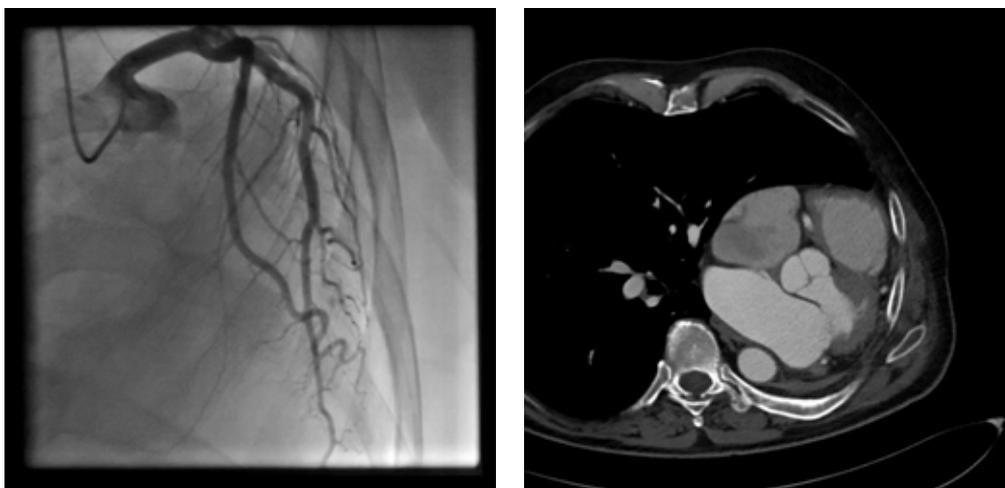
A) Coronary angiogram showing the left displacement of the heart.<sup>6</sup> B) CT showing the left-lateral displacement of the heart after pneumonectomy.
